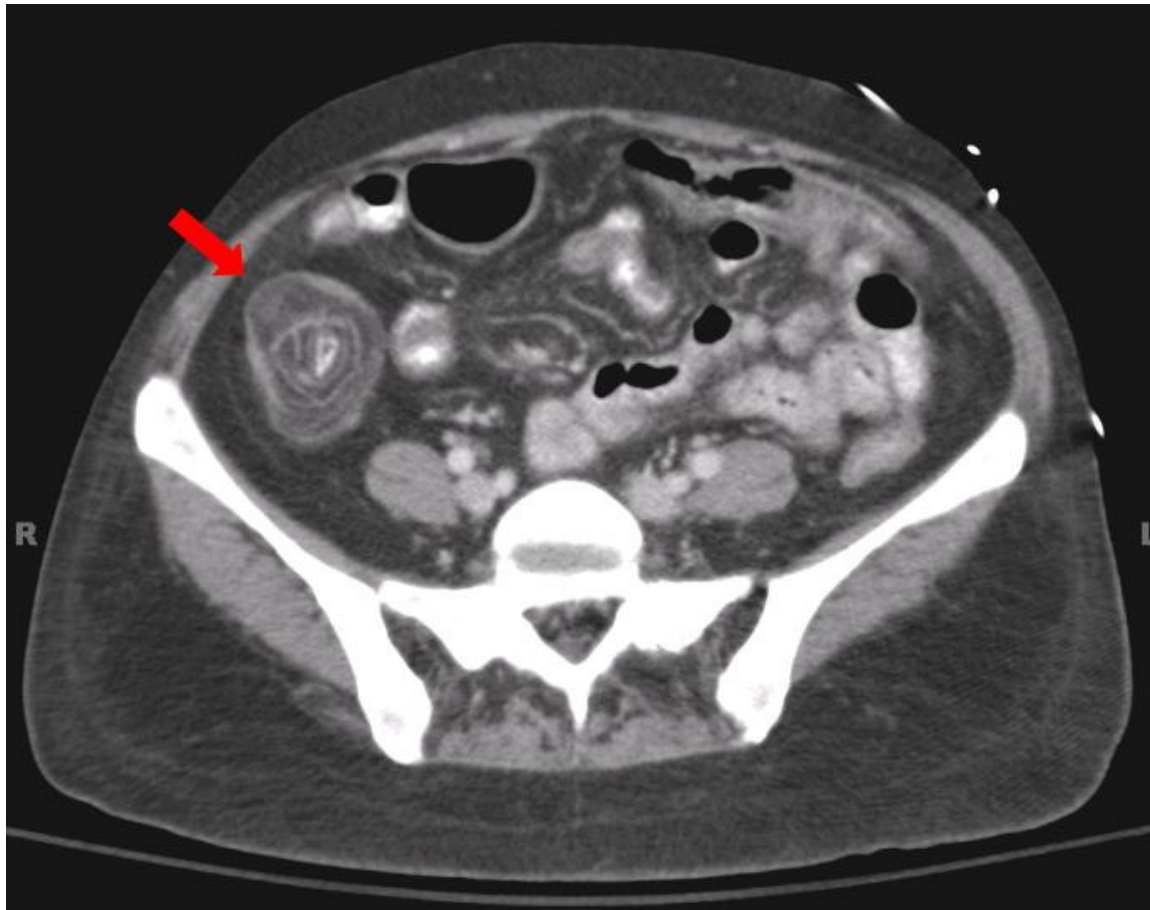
CT of the abdomen with target sign, suggesting ileocolic intussusception (see arrow).
